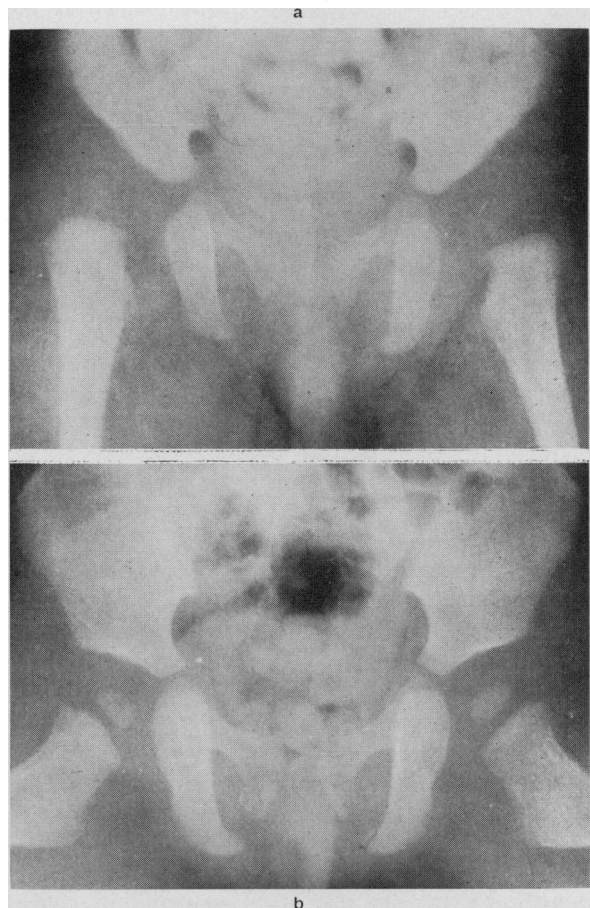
Reversibility of dysplasia. (a) Radiograph of the hips of a 4-month-old child with bilateral congenital dislocation of the hip. There is a moderate degree of dysplasia of the acetabulum on each side. (b) Radiograph of the same child one year after bilateral closed reduction; both hip joints have developed well, indicating that the acetabular dysplasia is reversible in the very young child provided a normal relationship between the femoral head and acetabulum has been restored and maintained.
